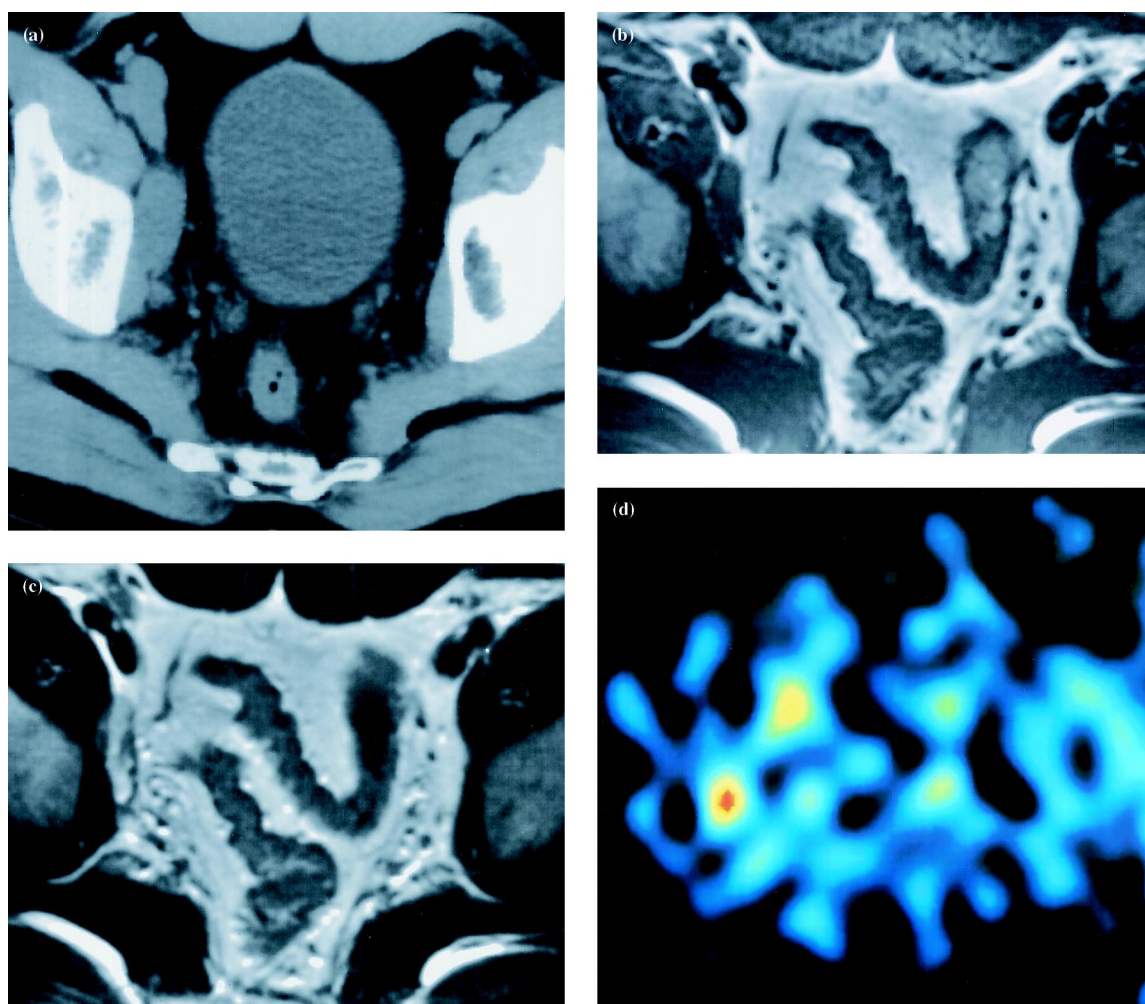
Multi-modality imaging in a non-Hodgkin's lymphoma (NHL). (a) A computed tomography scan following chemotherapy shows a residual soft tissue mass of nodal lymphoma on the right pelvic wall. The magnetic resonance imaging (MRI) scan shows that the mass has (b) a low signal intensity on T1-weighting and (c) a high signal intensity on T2-weighting. (d) ^{18}F FDG-positron emission tomography (PET) scan shows high uptake of ^{18}F FDG within the original mass. The patient relapsed in the abdomen 4 weeks after the MRI and PET studies.
